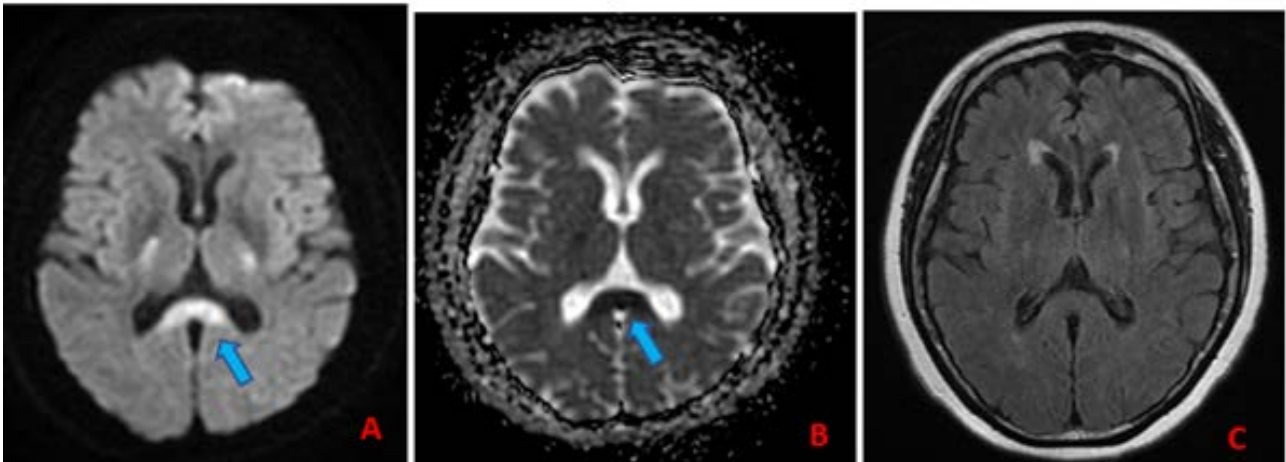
Brain MRI (June 2, 2021). (A) (diff B1000): hyper signal of the splenium of the corpus callosum (arrow); (B) (ADC): decreased ADC coefficient (arrow); (C) (FLAIR): no signal abnormality.
